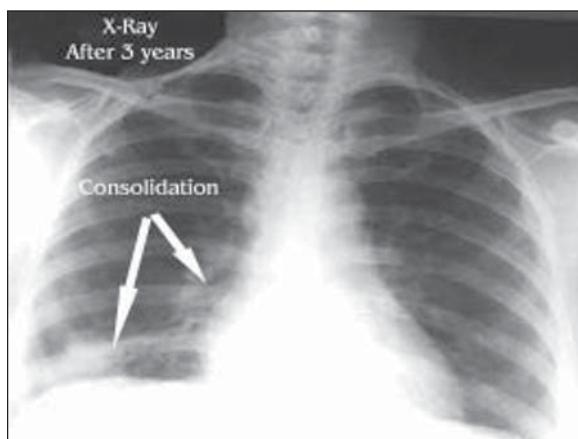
Xray chest showing consolidation of right middle cobe and partly also in right tower lobe
